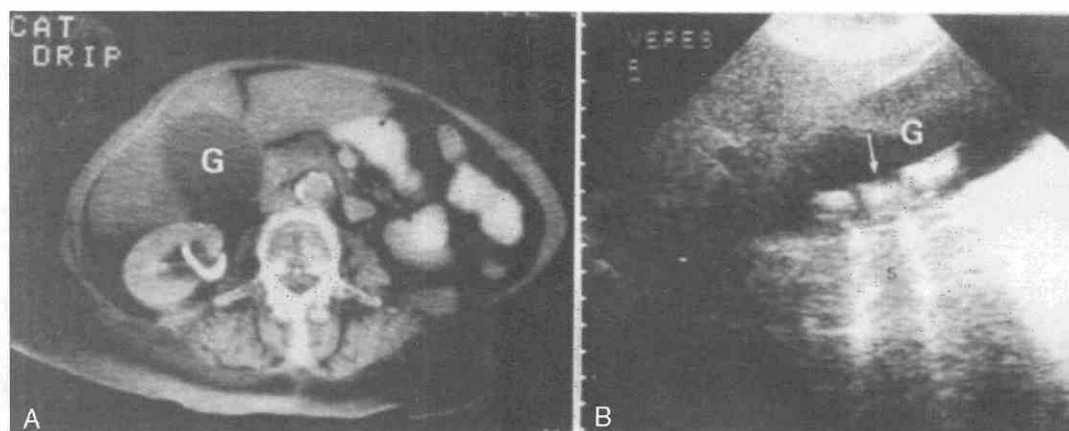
A, The gallbladder (G) is distended, but no filling defects are perceptible on this CT scan. B, Sagittal ultrasound scan through the gallbladder (G) demonstrates large, echogenic structures (arrow) within the gallbladder lumen, with associated acoustic shadowing (s) diagnostic of gallstones.
